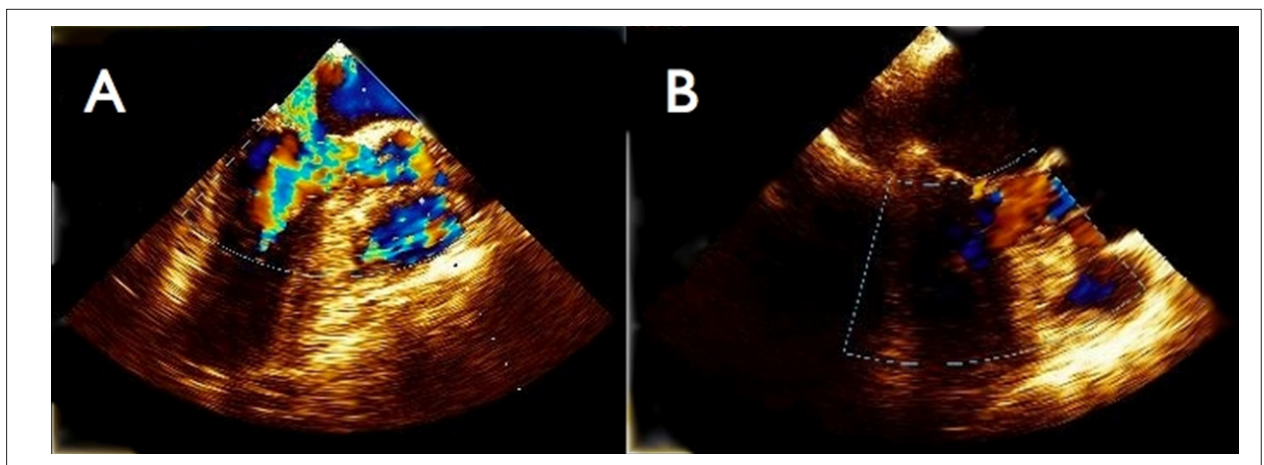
Image of EPLV with color Doppler by transesophageal echocardiogram at the medium esophagus level with 120° angle and challenging test with isoproterenol. Presence of turbulent flow (high gradient) in EPLV and significant mitral insufficiency before the myectomy (A), with disappearance of the turbulent flow in EPLV and absence of mitral insufficiency after the resection (B).
